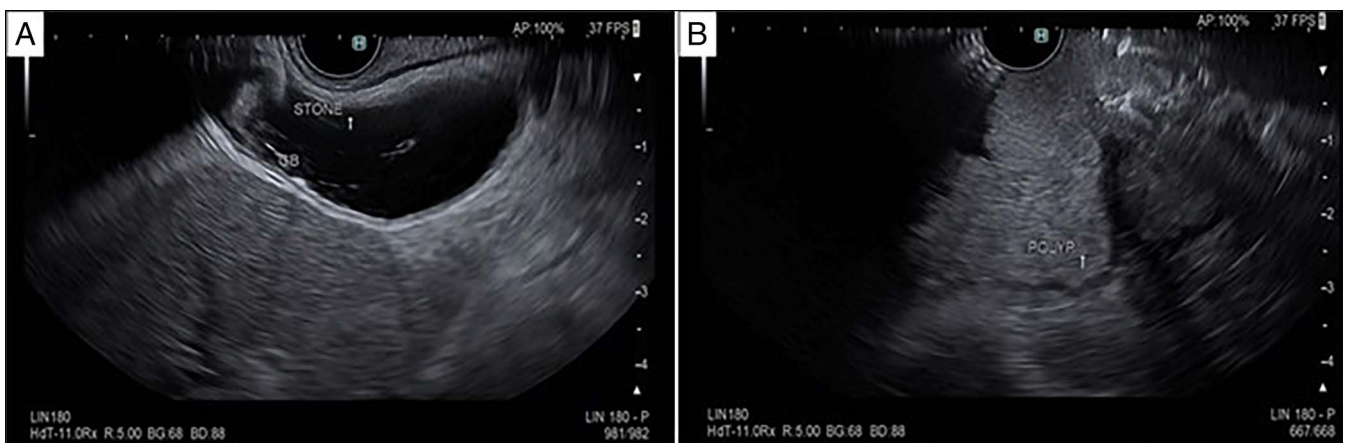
(A) EUS revealed the presence of gallstones and a thickened gallbladder wall; (B) EUS displayed the large hyperechoic polyp with well-defined borders. EUS, endoscopic ultrasound.
